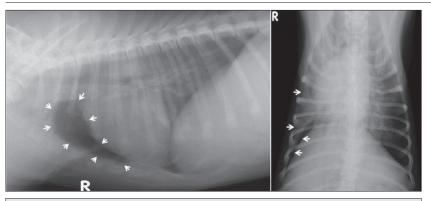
Radiograms of case 10 taken at 0th h, the ventrodorsal radiograph points out increased fluid density in the lung due to 3rd degree pulmonary contusion. There is minimal evidence of the pneumothorax, atelectatic caudal lung lobe border (*right arrows*) and free air accumulation (*left arrows*). The right lateral radiograph shows the free air accumulation and air-bronchogram pattern view due to more severe lung contusion
